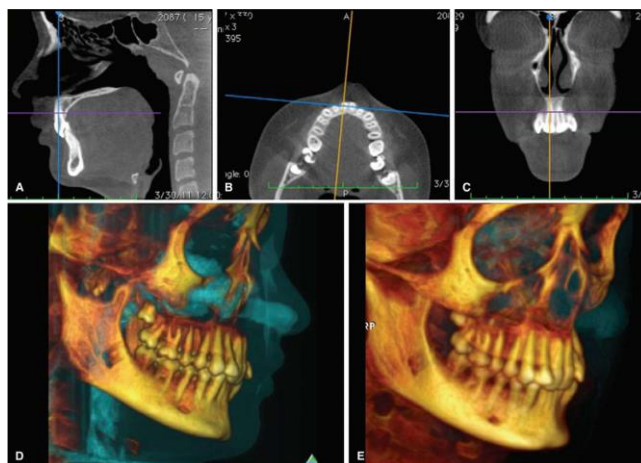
CBCT showing alveolar boundary conditions
